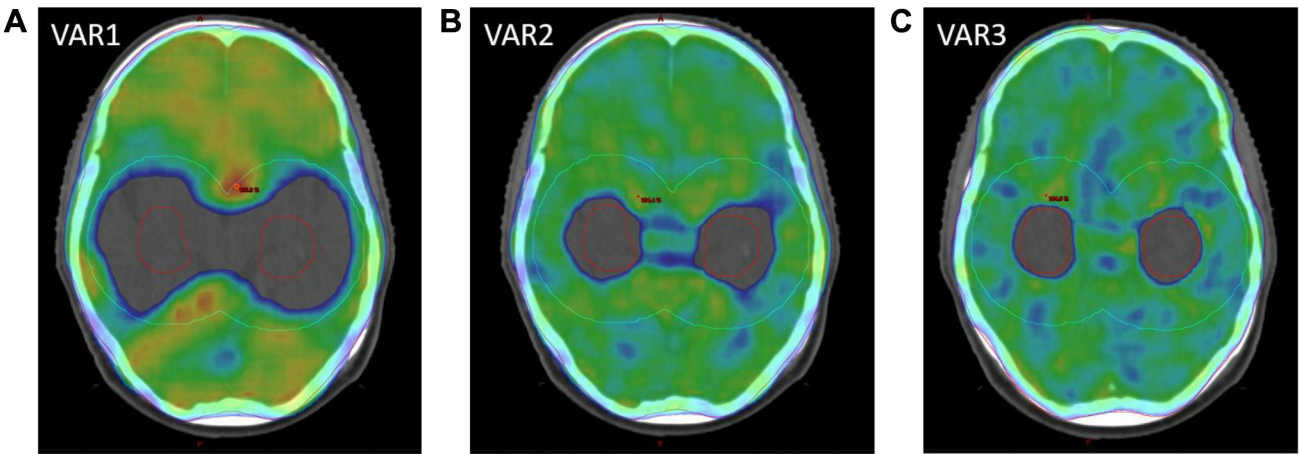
Whole brain irradiation with hippocampus sparing. Dose coverage in color wash from 95% to 107%. Representative transversal plane in CT#2. Irradiation plans were calculated according to the planning type with three arc rotations (3ROT). A) Plan for variant 1 (VAR 1). B) Plan for variant 2 (VAR 2). C) Plan for variant 3 (VAR 3). The planning target volume (PTV) is shown in red, and the auxiliary structure volume of interest 1 (VOI1) in cyan.
